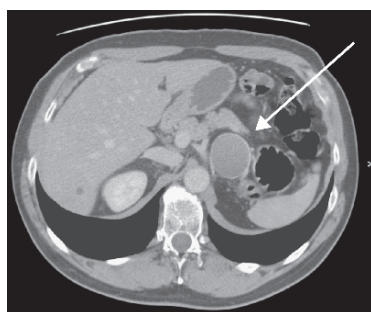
Low density pheochromocytoma. Right adrenal mass representing pathologically proven pheochromocytoma which measured 10HU on non-contrast CT (arrow)
